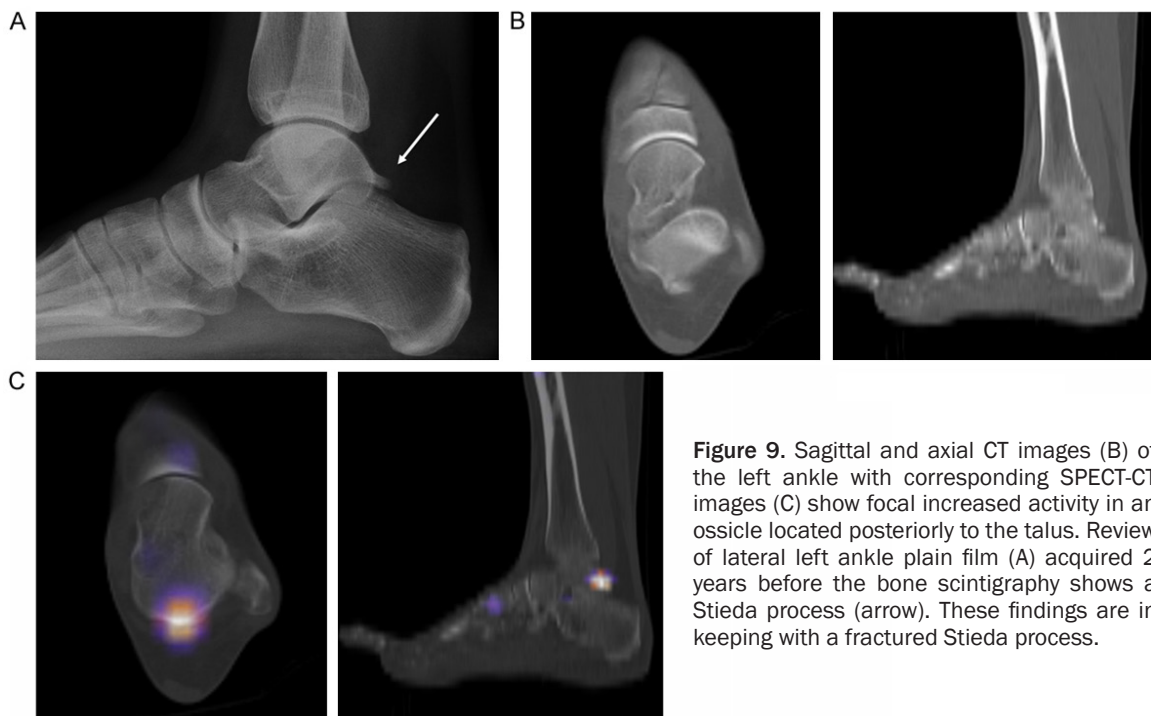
Sagittal and axial CT images (B) of the left ankle with corresponding SPECT-CT images (C) show focal increased activity in an ossicle located posteriorly to the talus. Review of lateral left ankle plain film (A) acquired 2 years before the bone scintigraphy shows a Stieda process (arrow). These findings are in keeping with a fractured Stieda process.
